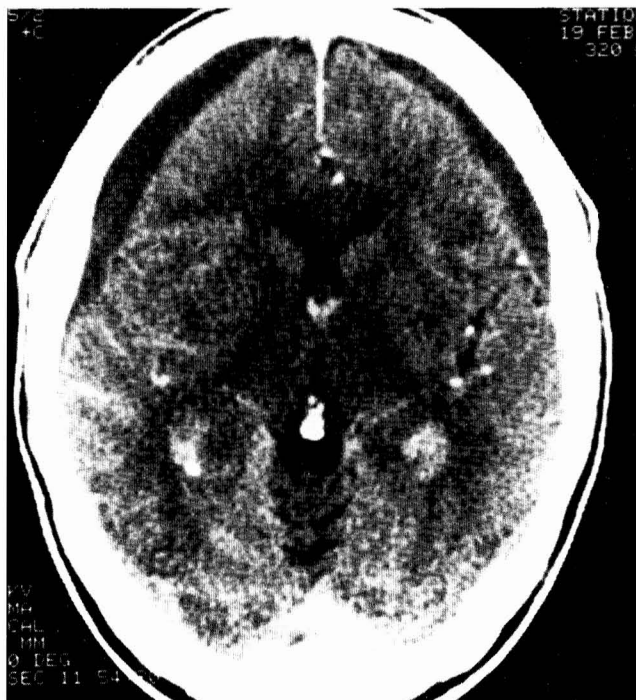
CT scan shows bilateral subdural hematomas, effacement of the cortical sulci, and ventricular compression.
